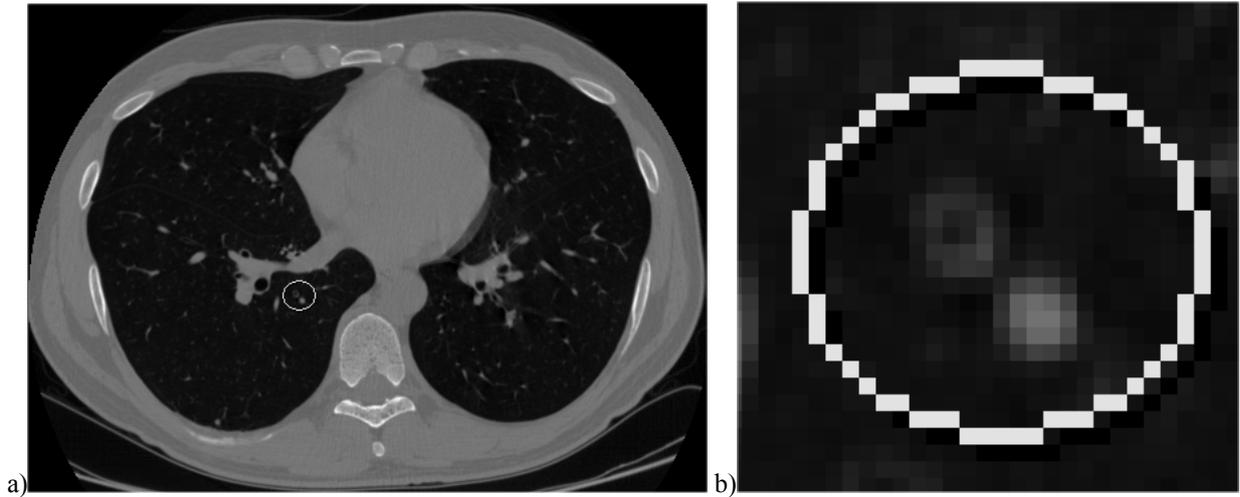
a) CT image with indicate bronchi/vessel pair.
